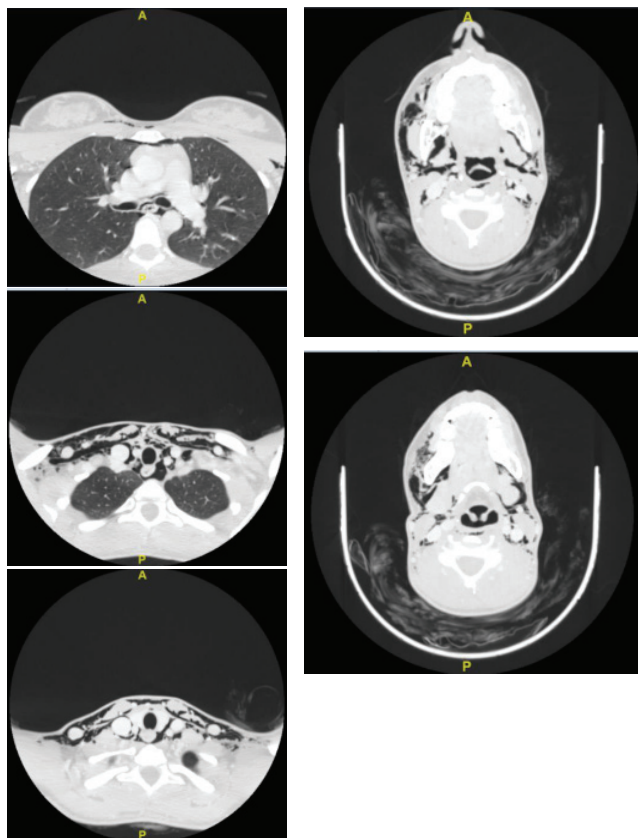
Non-contrast enhanced cervical and thoracic CT scan showing subcutaneous emphysema with pneumomediastinum.
